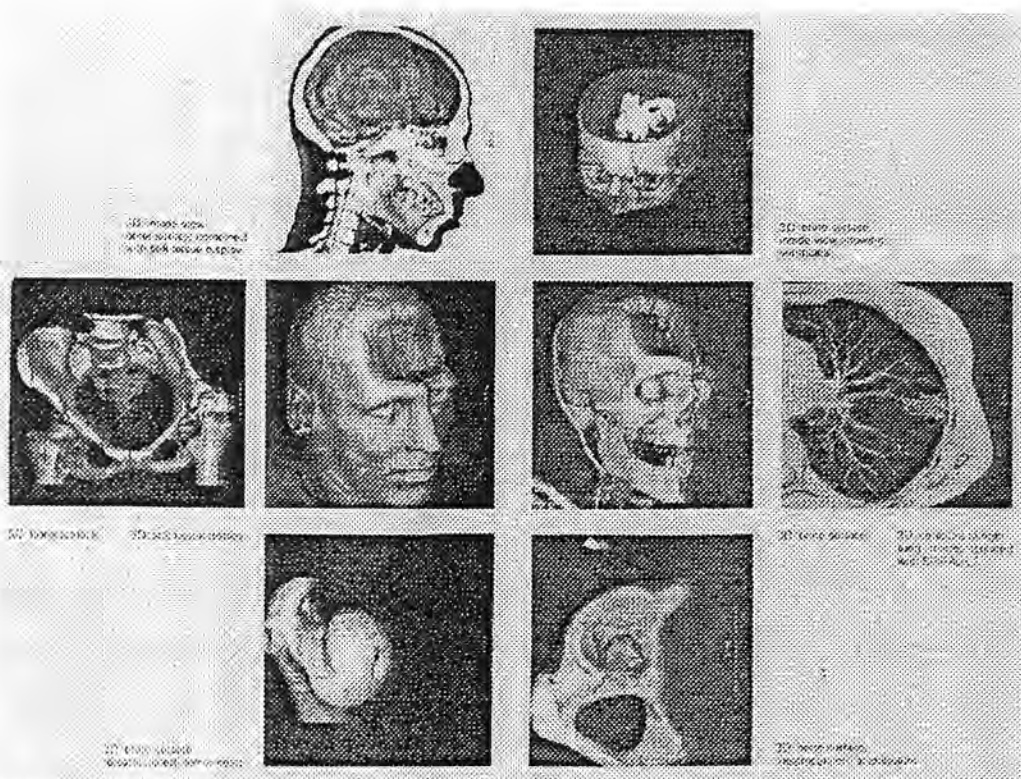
Examples of 3D images now available through CT technology (Seeram 1994).
